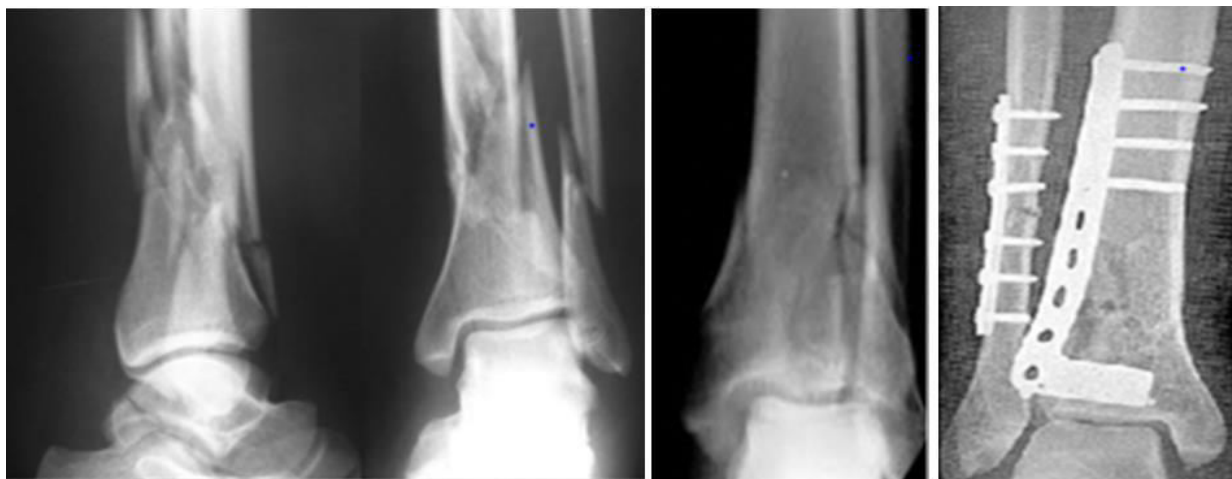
Lateral Plating and X-Ray.
